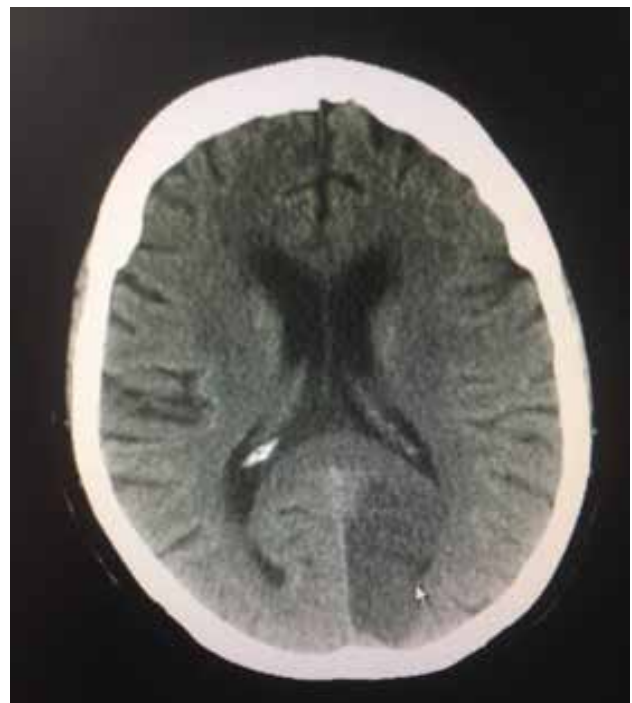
CT scan brain showing left occipital infarct. Her anaemia was investigated. Her OGD was normal. Her colonoscopy revealed angiodysplasia of colon, argon plasma coagulation was done on caecum.
